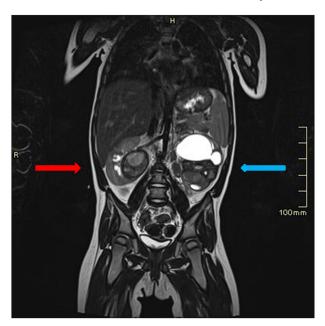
Tumor extension on MRI (T2W coronal series) at response assessment before surgery (patient 2). Left-sided tumor was surgically treated with total nephrectomy (blue arrow). Right-sided tumor was treated with enucleation and brachytherapy (red arrow).
